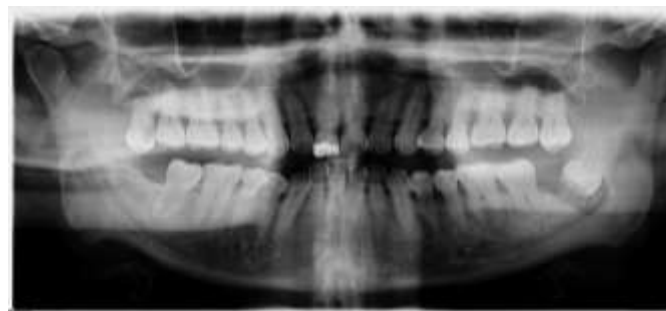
The panoramic radiograph
